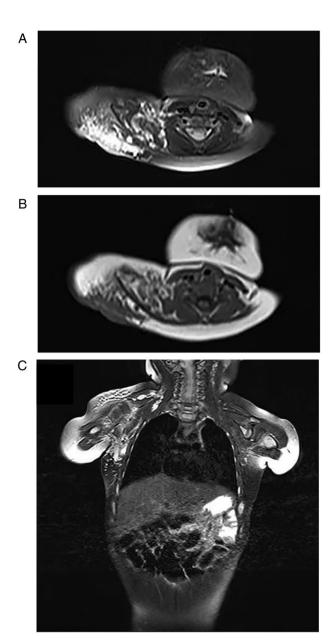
KHE with diffuse abnormal signal with ill-defined border and irregular shape in MRI. (A) Horizontal plane shows KHE lesion involved right neck and scapula with hyperintense signal on T2WI in fat saturation sequence and (B) low-intensity on T1WI. (C) Coronal plane shows lesion in right axilla, shoulder and neck with high signal on T2WI in fat saturation sequence. KHE, Kaposiform hemangioendothelioma; MRI, magnetic resonance imaging.
